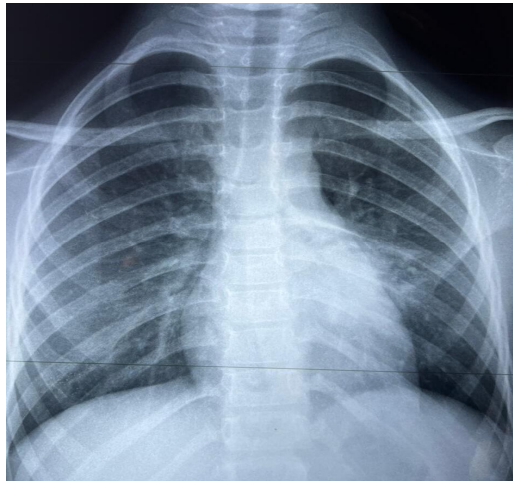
the chest X-ray with a left paracardial opacity without cardiomegaly.
